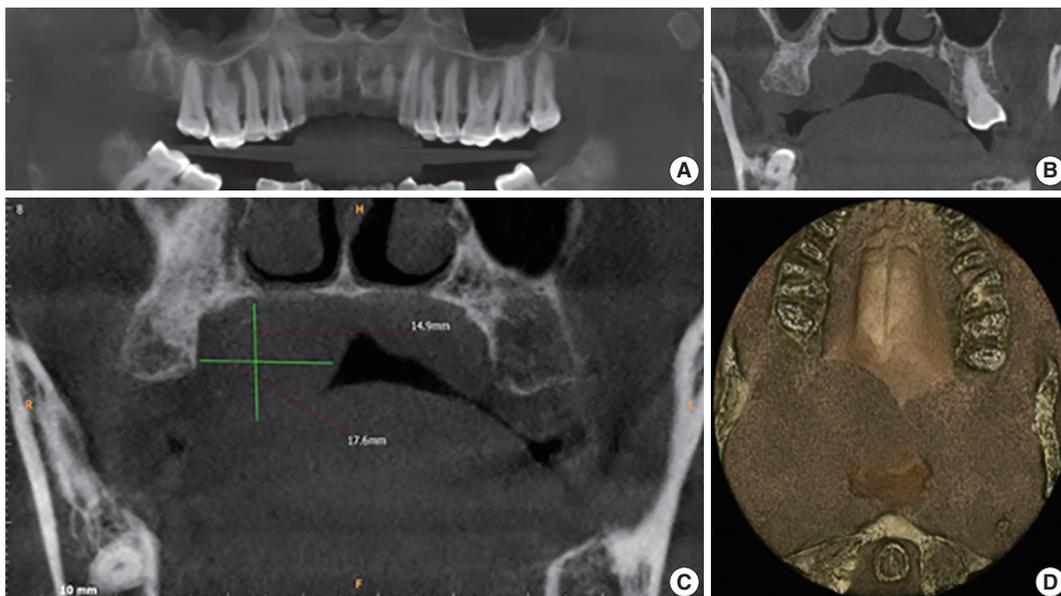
(A) Reconstructed panoramic image shows the polyp at the level of the mid right maxillary sinus. (B) Axial section shows inflamed sinus lining involving the right maxillary sinus. (C) Cone beam computed tomography (CBCT) mid-coronal section of the right maxillary third molar (18) showing the soft tissue shadow palatally. (D) Two-three dimensional CBCT image showing the antero-posterior extent of the swelling.
